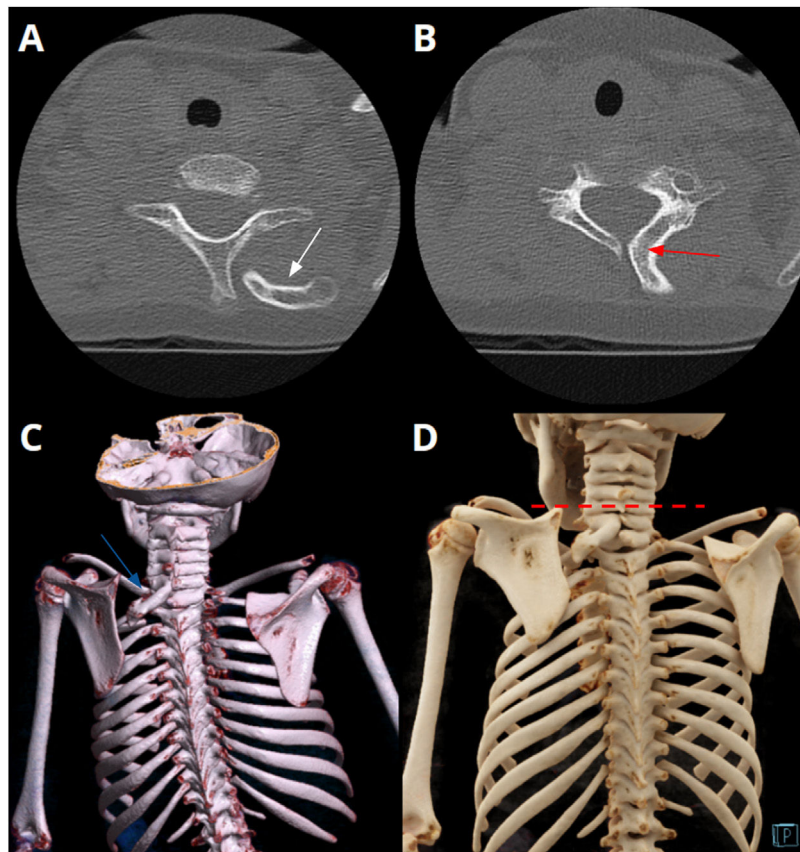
A and B) Simple CT of the cervical spine, axial plane in bone window, with curved bone structure (white arrow) fused to the vertebral lamina of C7 (red arrow), suggestive of an omovertebral bone. C and D) 3D-VRT reconstructions in which the morphology and direction of the omovertebral bone can be observed in more detail (blue arrow) and the elevation and well-defined rotation of the left scapula, whose superomedial border lies above the C5 spinous process (dotted red line) (Rigault classification Grade III).
